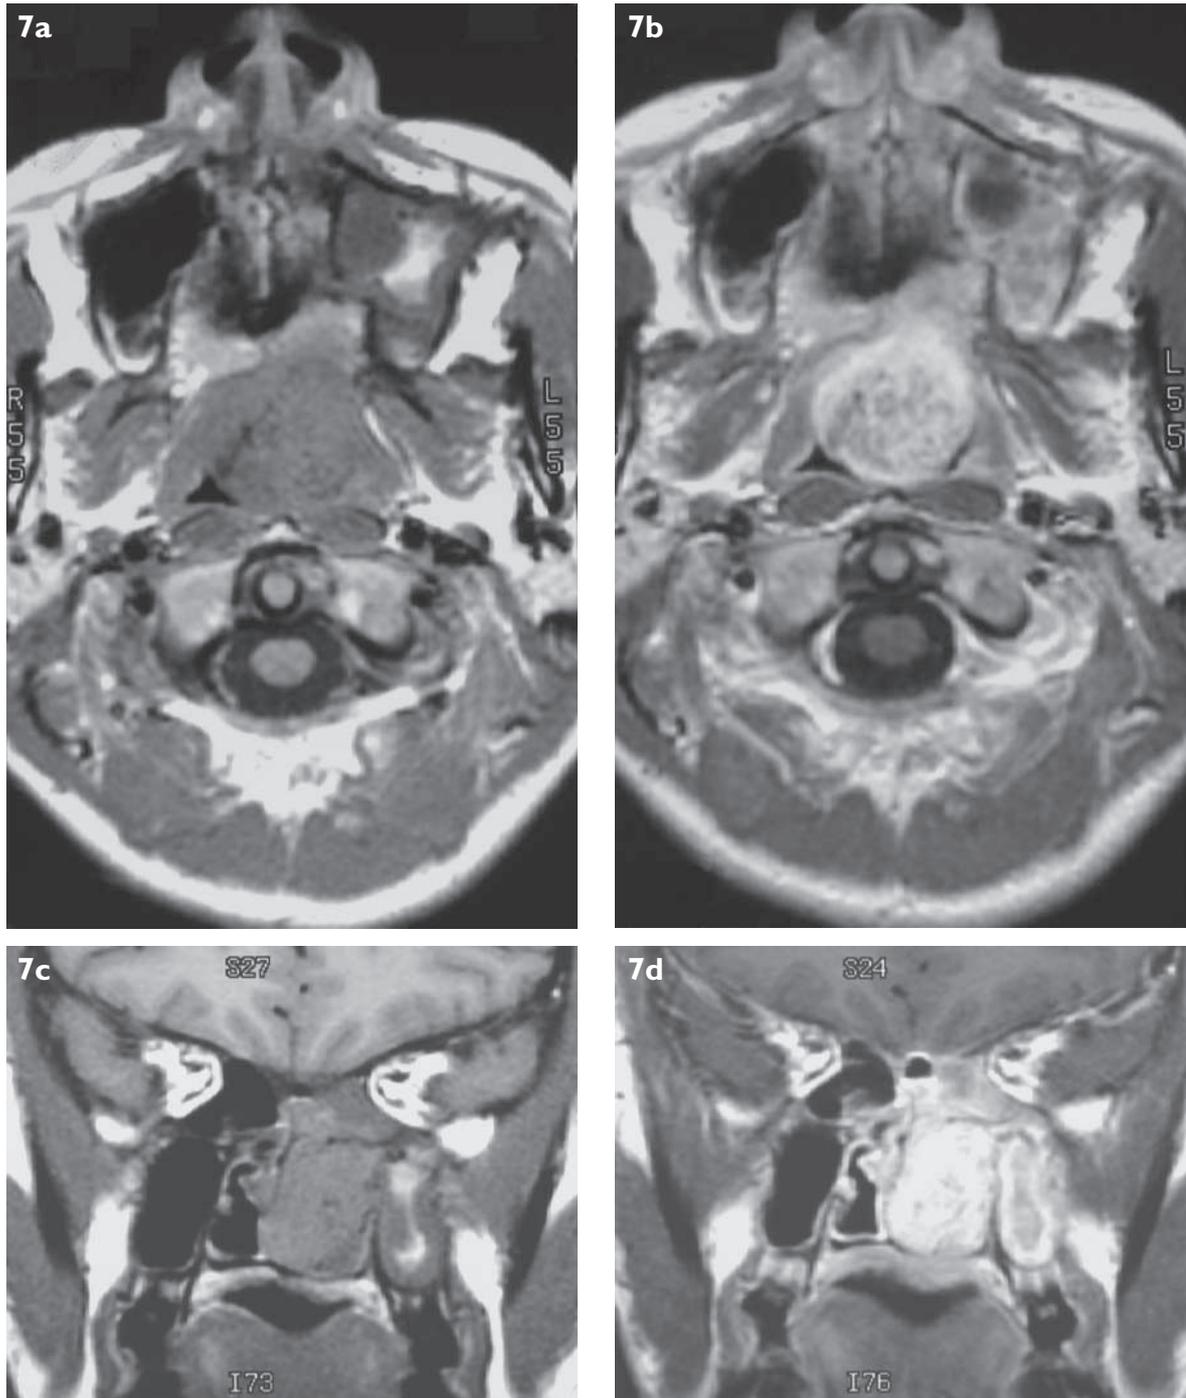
MR imaging appearances of juvenile nasopharyngeal angiofibroma. (a) Axial T1-W MR image shows a mass in the nasopharynx that is isointense to muscle. (b) Enhanced axial T1-W MR image shows intense enhancement of the mass with intra-lesional flow voids. (c) Coronal T1-W MR image shows an isointense (to muscle) mass that extends into left sphenoidal sinus. (d) Enhanced coronal T1-W MR image shows intense enhancement of the mass with intra-lesional flow voids.
